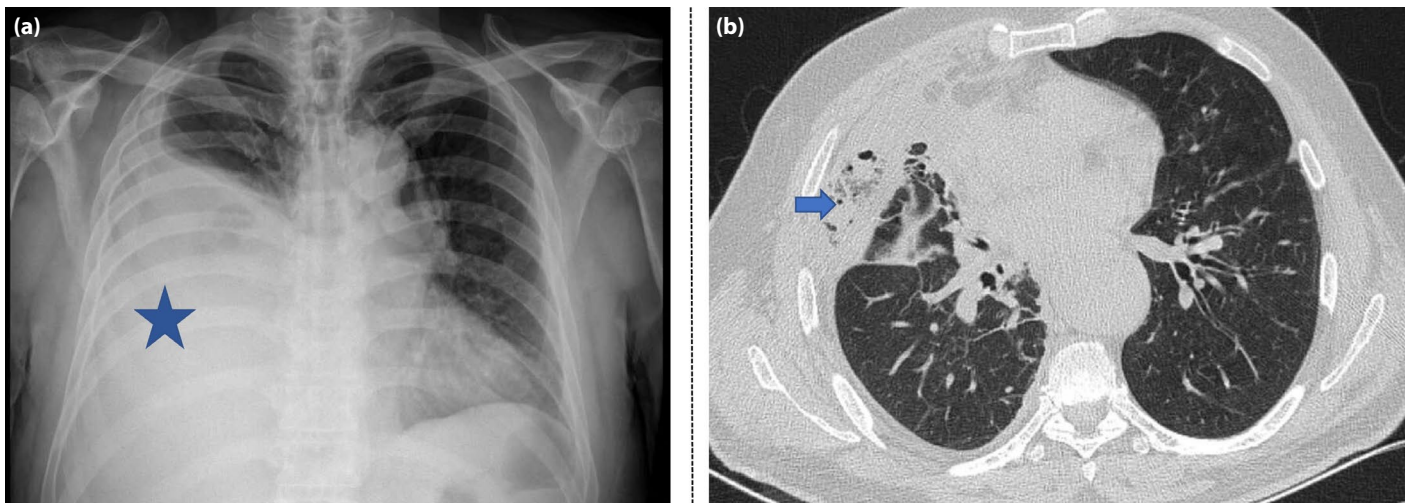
(a) Initial chest X-ray. (b) Post-drainage X-ray displaying an air-fluid level and an expansion defect in the anterior upper lobe of the right lung.
